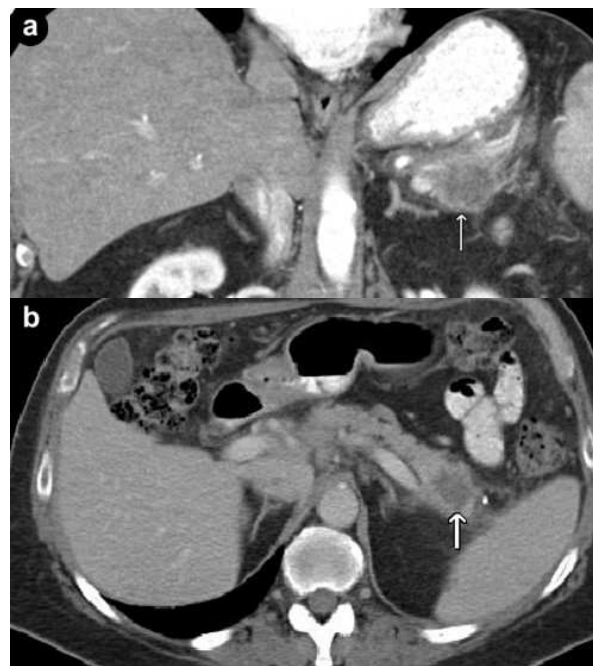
The coronal (a.) and axial (b.) CT scan views demonstrating a mass in the tail of the pancreas (arrow) characteristic of a pancreatic adenocarcinoma.
